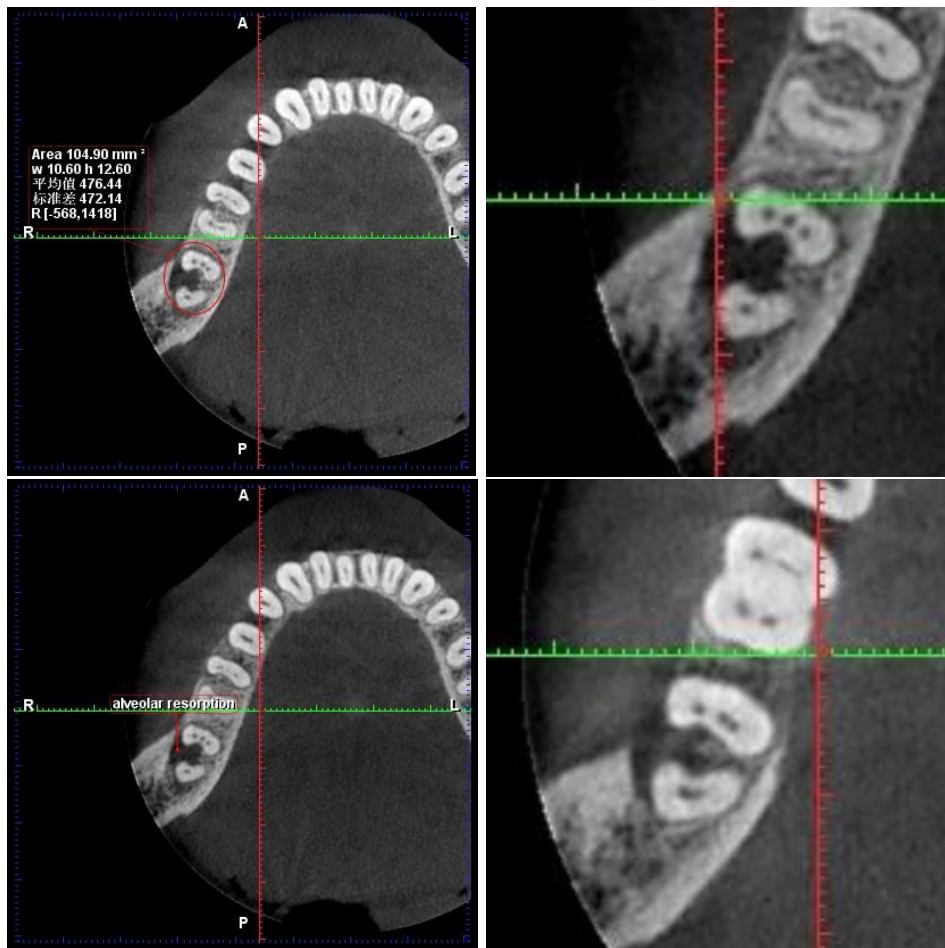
Pre-operative CBCT
